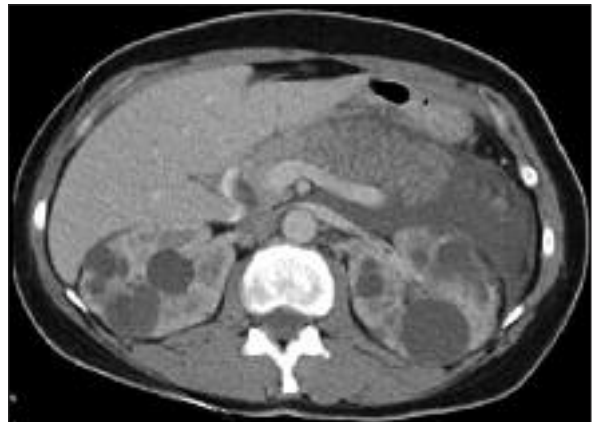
The pancreatic tail was edematous and surrounded by peripancreatic fluid neighboring the largest cyst of the left kidney in ultrasound and CT. The left peri-pararenal fluid collection may reflect a possibility of a cyst rupture located at the middle port of left kidney.
